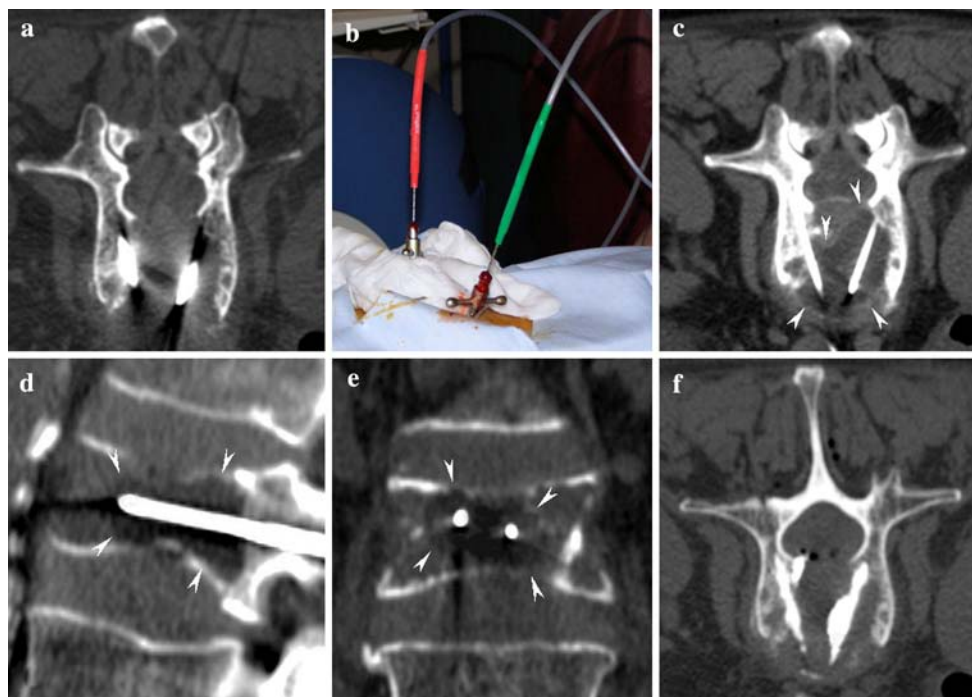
(A) Axial image showing positioning of the 13G biopsy needles under CT control. (B) Cryoprobes coaxially introduced through the biopsy needles. (C–E) "Kissing" iceballs visualized as
